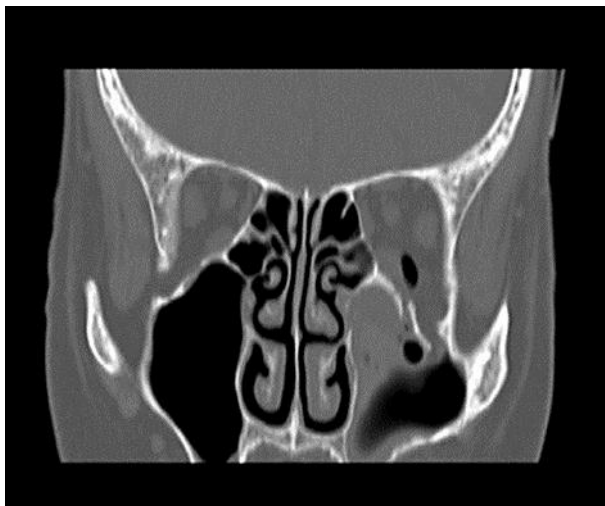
Head computed tomography image immediately after injury. A blowout fracture of the inferior wall of the left orbit accompanied by soft tissue prolapsing into the orbit is presented. Accumulated hemorrhage in the maxillary sinus is also observed.
